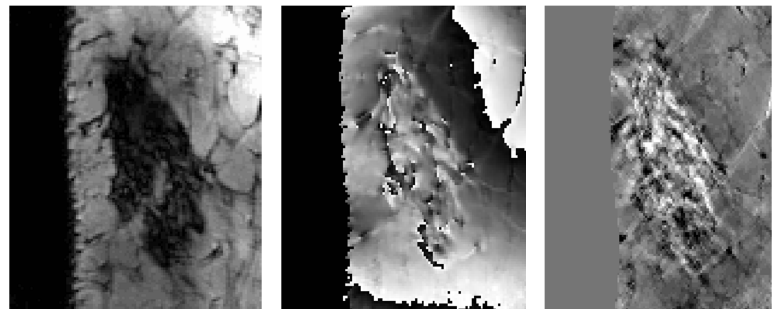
Example of a fresh (40 min) artificial s.c. hematoma in MRI. Magnitude image (left), raw (wrapped) phase image (middle; TE=13.7 ms), and quantitative susceptibility map (right; from black to white: -0.4 ppm to 0.45 ppm).
